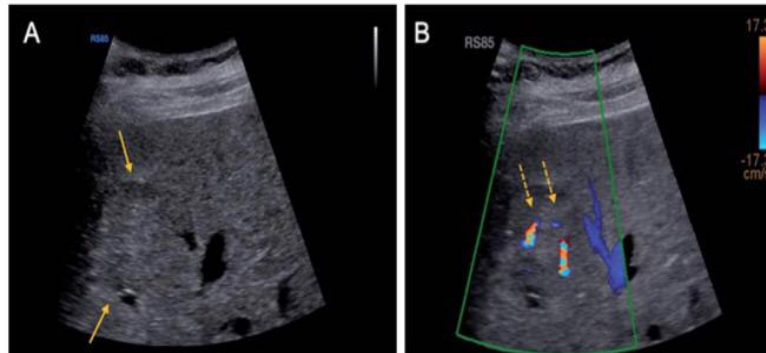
40-year-old female with no relevant medical history. A: 3 cm isoechoic lesion in segment 8 found in B-Mode sonography (arrows). B: Color Doppler image demonstrates prominent feeding vessels (arrows).
